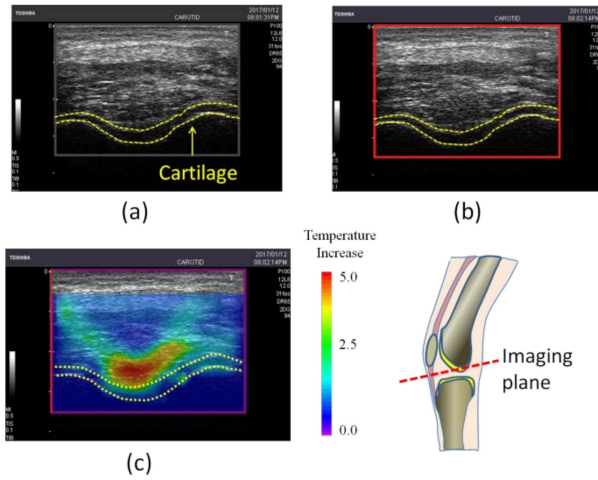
Ultrasound knee images and calculated temperature distribution.
